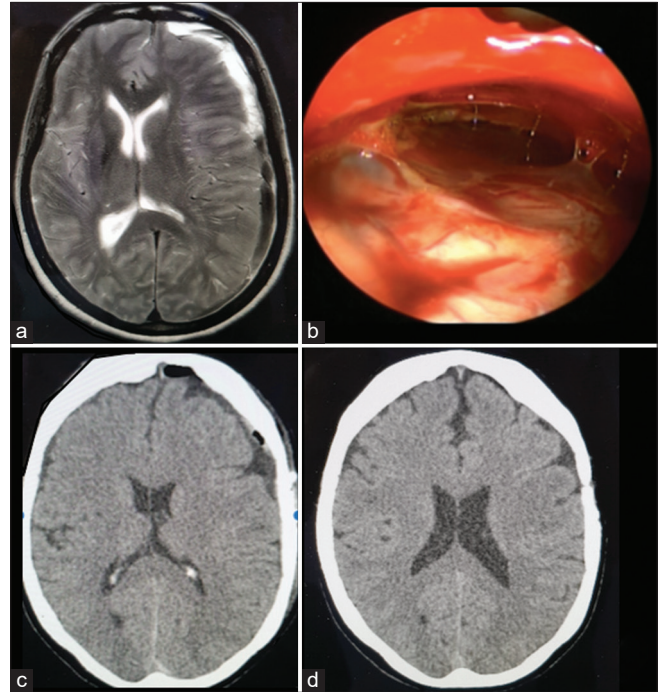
Images of a 55-year patient operated with the described technique. (a) The preoperative T2-weighted scan showing the septations in the subdural cavity with contralateral midline shift. (b) The endoscopic view of septations. (c) The postoperative day 1 CT showing good evacuation of clots and septa. (d) A 1-year follow-up scan showing good results.
